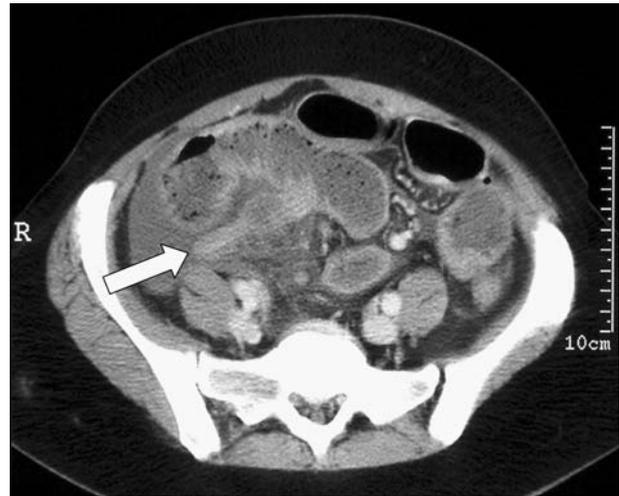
CT scan of pelvis showing inflamed appendix (arrow) with pericaecal fluid
